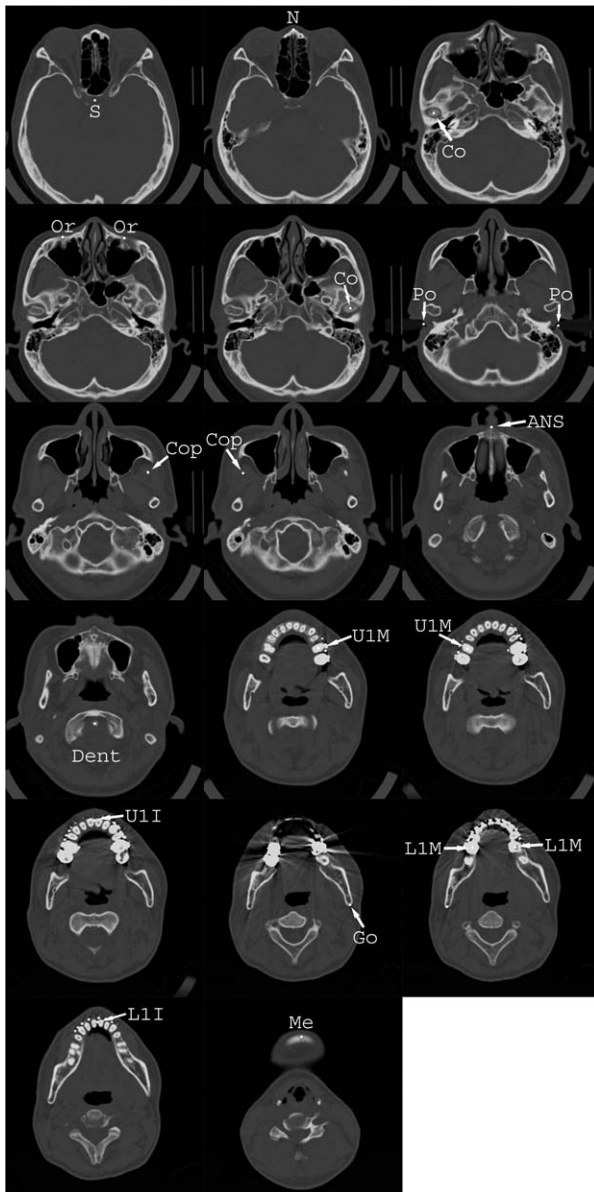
Anatomical landmarks for 3D-CT are plotted on the axial CT images.
